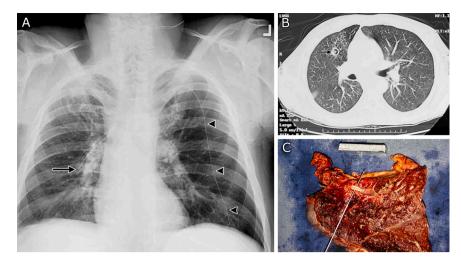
Pulmonary findings at last admission and at autopsy. *Panel A*, PA view showing Denver shunt coursing upward along the posterior-lateral chest wall (arrowheads) and extending across the midline to end in the right midlung field (arrow). *Panel B*, Chest CT scan showing catheter tip (arrow) protruding into a cavity in the right upper lobe at the level just caudal to the bifurcation of the mainstem bronchi. *Panel C*, Gross pathology at autopsy with the Denver shunt catheter tubing exposed above an underlying probe. The photo is of the right upper lobe, which had been bread-knifed to examine lung parenchyma. Note the extensive surrounding hemorrhage and marked pleural thickening.
